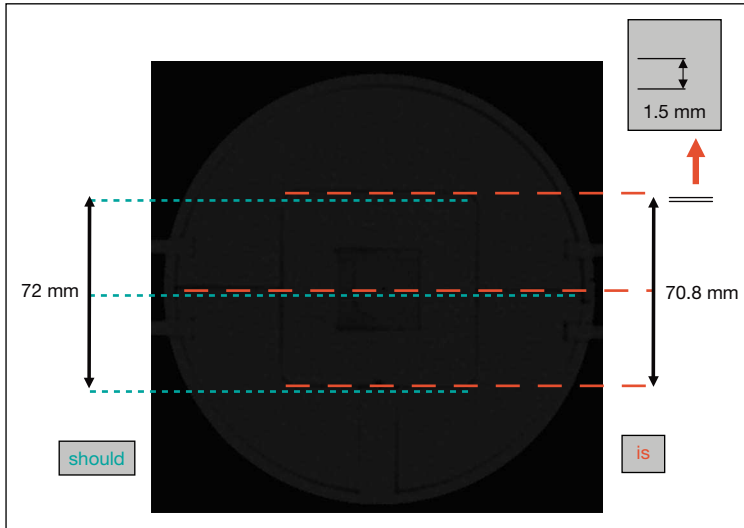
Evaluation after the final step of optimization. The impact of chemical shift and susceptibility artefacts on the accuracy of MR imaging is shown. The set of images is compressed (in this example by 1.2 mm) and a shift in z-direction can be observed (1.5 mm).
